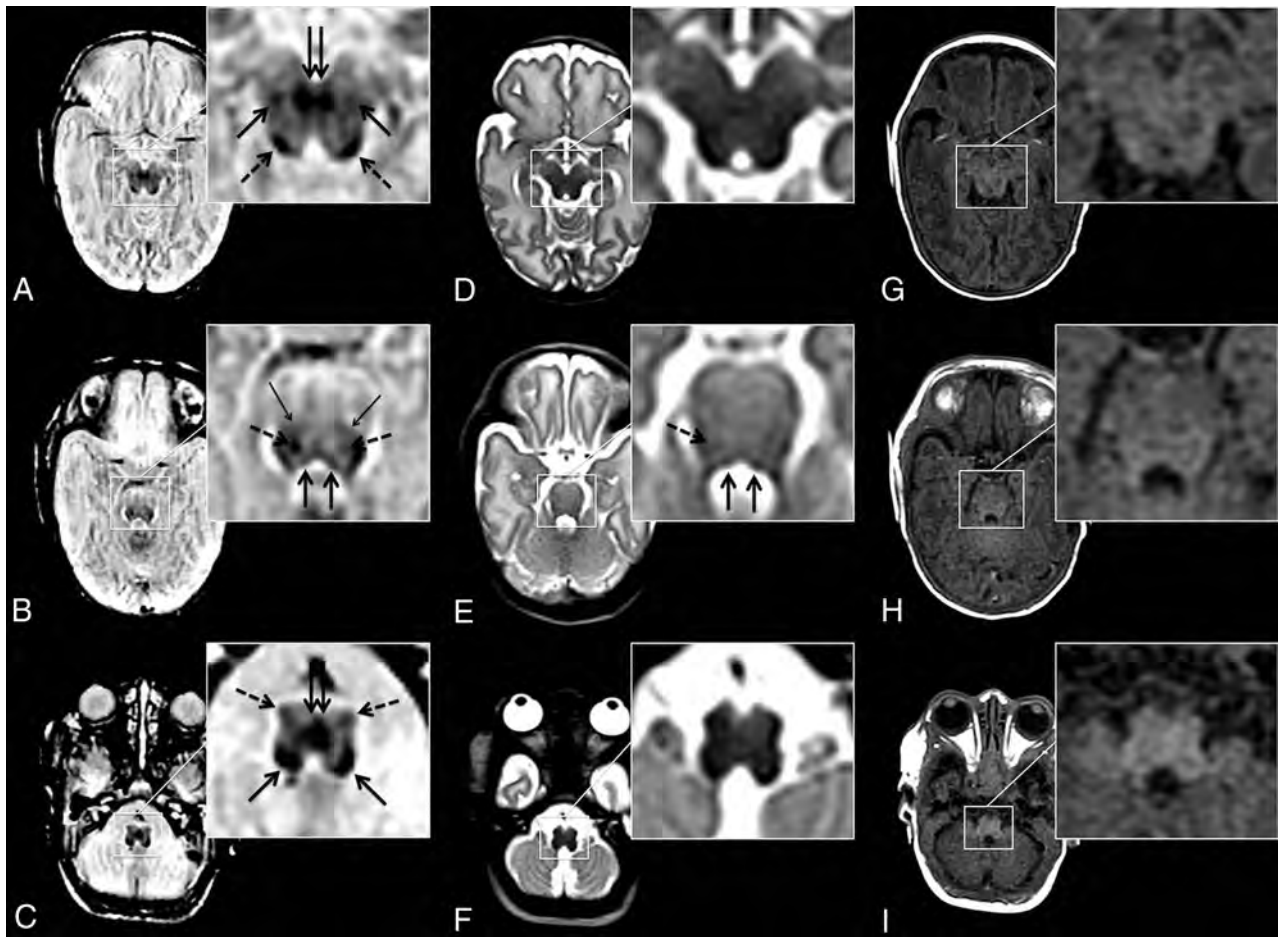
Neonatal brainstem anatomy is shown in an infant born at 24 + 3 weeks' GA (MR imaging at 38 + 0 weeks postmenstrual age) at the level of the midbrain (A, D, and G), pons (B, E, and H), and the medulla oblongata (C, F, and I) on syWMSS data (A, B, and C), conventional T2-weighted contrasts (D, E, and F), and conventional T1-weighted contrasts (G, H, and I). syWMSS data (A, B, and C) depict early myelinating structures: DSCP (double arrow in A); ML (arrows in A; thin arrows in B) and its decussation (double arrow in C); inferior colliculus (dotted arrows in A); CTT (dotted arrows in B); MLF (arrows in B); amiculum of the inferior olivary nucleus (dotted arrows in C); and inferior cerebellar peduncle (arrows in C). Pontine bundles are depicted sufficiently on T2-weighted imaging data (D, E, and F) (CTT [dotted arrow in E] and MLF [arrows in E]). On the basis of T1-weighted contrasts, a reliable delineation of brainstem pathways is limited (G, H, and I). Center/width at the reader's discretion.
